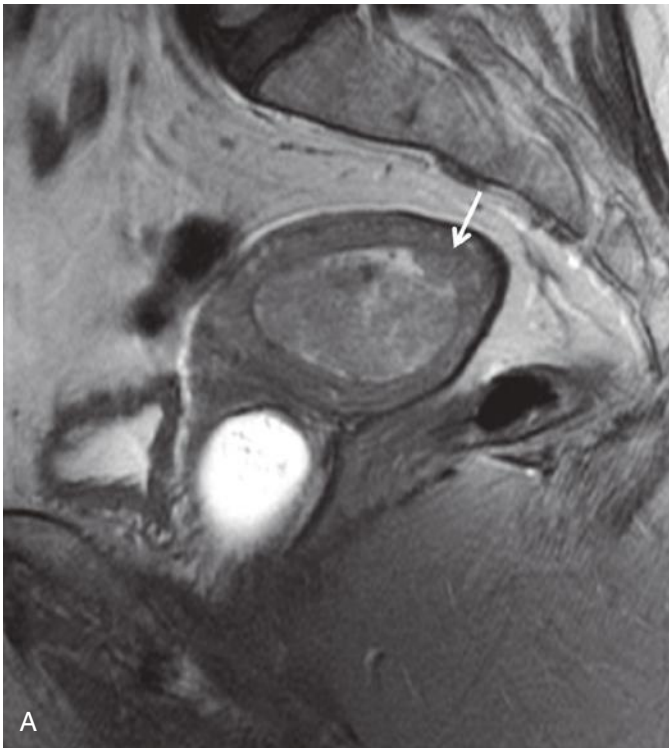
Stage IB endometrial cancer. Sagittal T2-weighted image demonstrates a large hyperintense mass (*asterisk*) invading through more than 50% of the myometrial wall thickness anteriorly (*arrow*).
